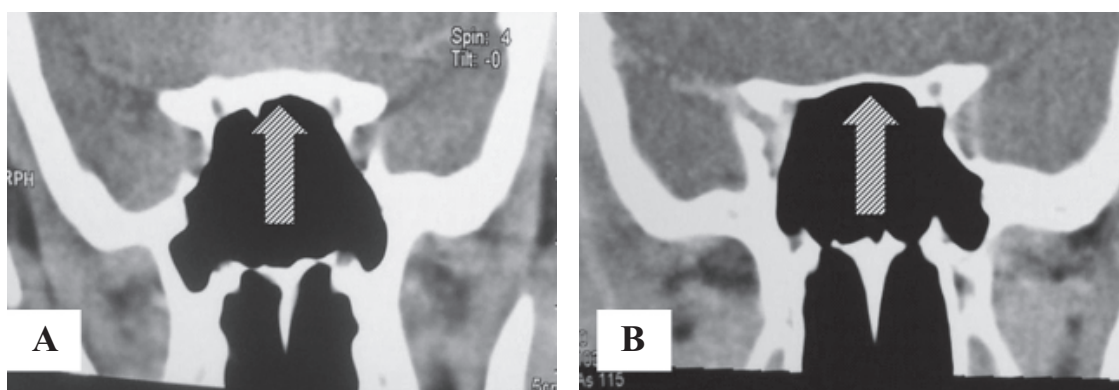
CT brain, coronal view. Figure 4A: CT brain of the patient showing hyperostosis of the sphenoid bony. Figure 4B: CT brain of another patient showing normal sphenoid bone thickness.
